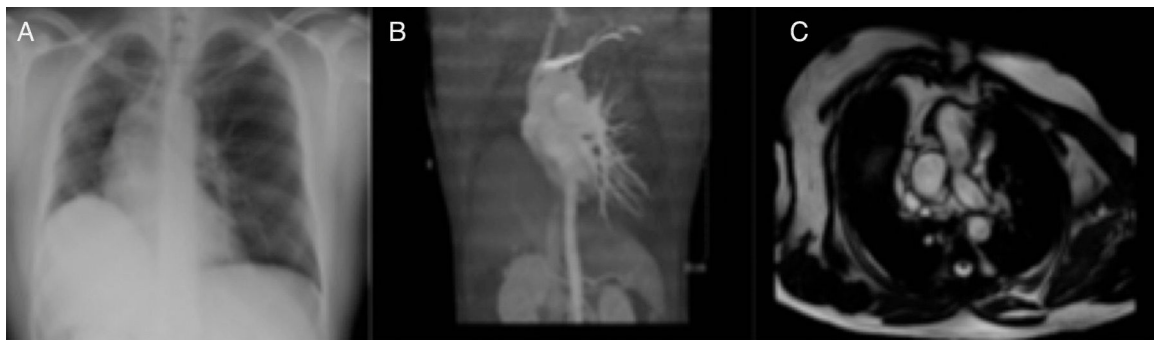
(A) Chest radiograph showing elevation of the right hemidiaphragm. (B) CT reconstruction showing absence of the right pulmonary artery. (C) Cardiac magnetic resonance imaging slice with right pulmonary artery agenesis and partial agenesis of the right lung.
